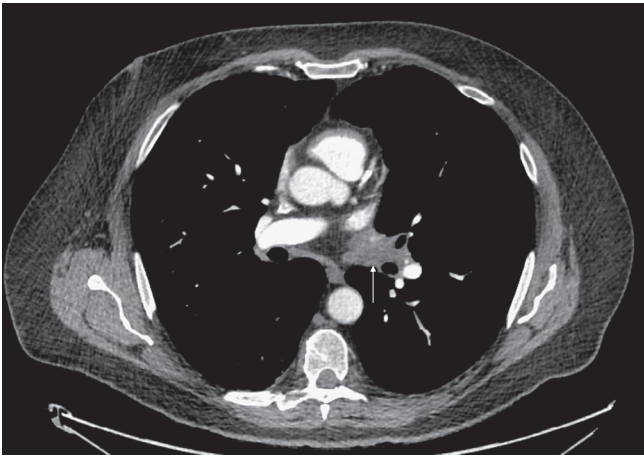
Computed tomography (soft tissue window) demonstrates an ill-defined left hilar mass surrounding the left pulmonary vein (arrow).
